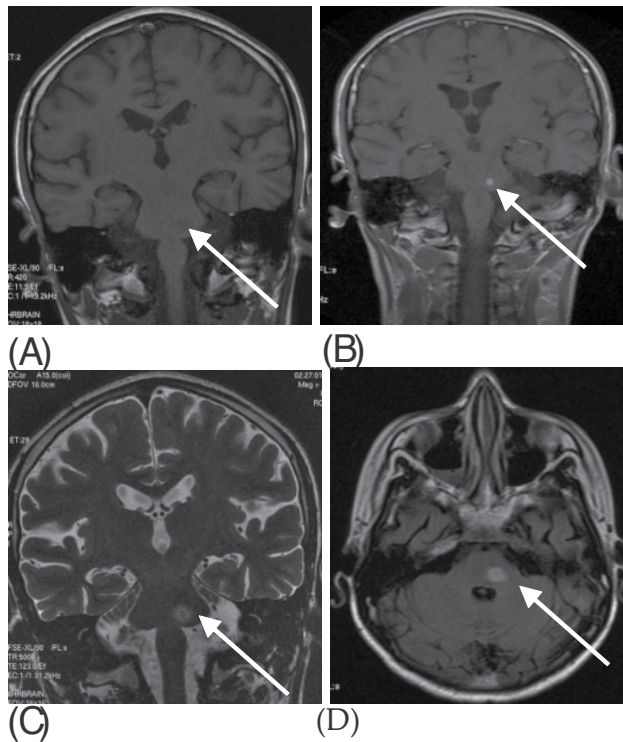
Cranio-cerebral MRI, showing left pontine tuberculoma in a 16 year-old patient previously diagnosed and undergoing treated for lymph node TB for the past 2 months and recently diagnosed with HIV infection. The patient also associated HBV and CMV infection and oral candidiasis. On admission the patient was in coma. The laboratory data displayed a CD4 count of 24 cells/mm³ and RNA HIV 1064973copies/ml. Final diagnosis was NeuroIRIS TB (tuberculoma). The CSF disclosed no changes. The clinical evolution was favourable. A: coronal T₁ weighted image demonstrating left pontine paramedian nodular lesion of 4 mm surrounded by perilesional edema (discrete hyposignal). B: coronal section T₁ postcontrast shows hypersignal; C- coronal section T₂ and D- axial FLAIR section show intense contrast uptake and no diffusion restriction.
